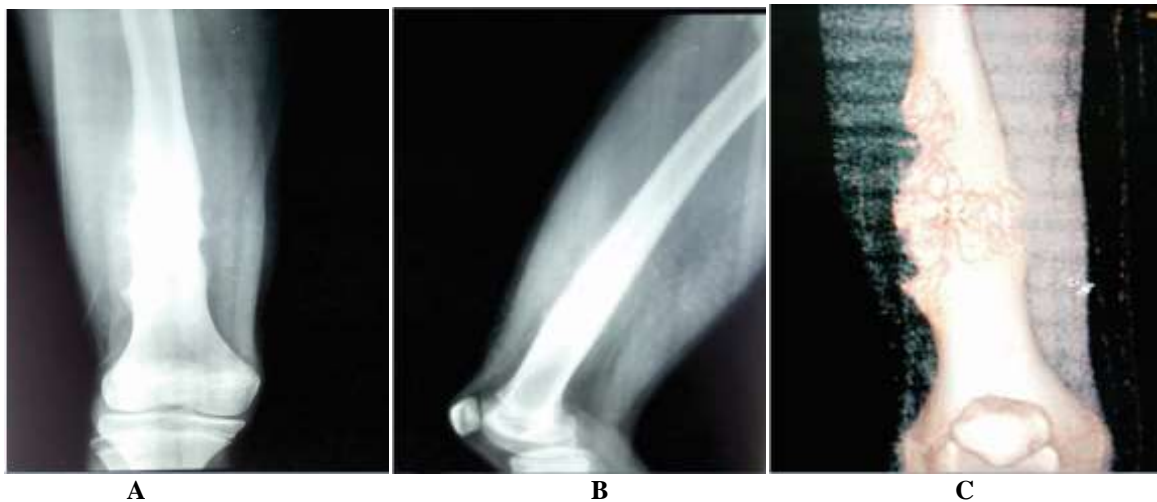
X-ray AP (A), Lateral view (B) and 3D (C) image of right thigh shows interrupted, sunburst periosteal reaction seen involving the distal femoral diaphysis with saucerization along the lateral femoral aspect, obliteration of medullary cavity and soft tissue swelling.
